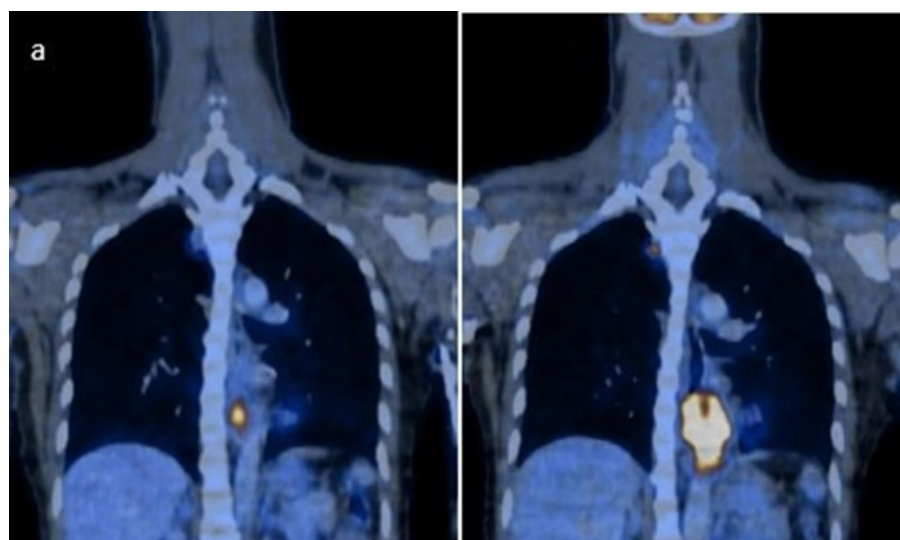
a. After 2 cycles of chemotherapy, FDG PET/CT reveals good response to therapy as evidenced by gross and metabolic regression of the esophageal mass and upper paratracheal lymph node. b. Follow-up PET/CT scan after additional cycle of chemotherapy shows interval gross and metabolic progression of the esophageal and upper paratracheal lymph node.
